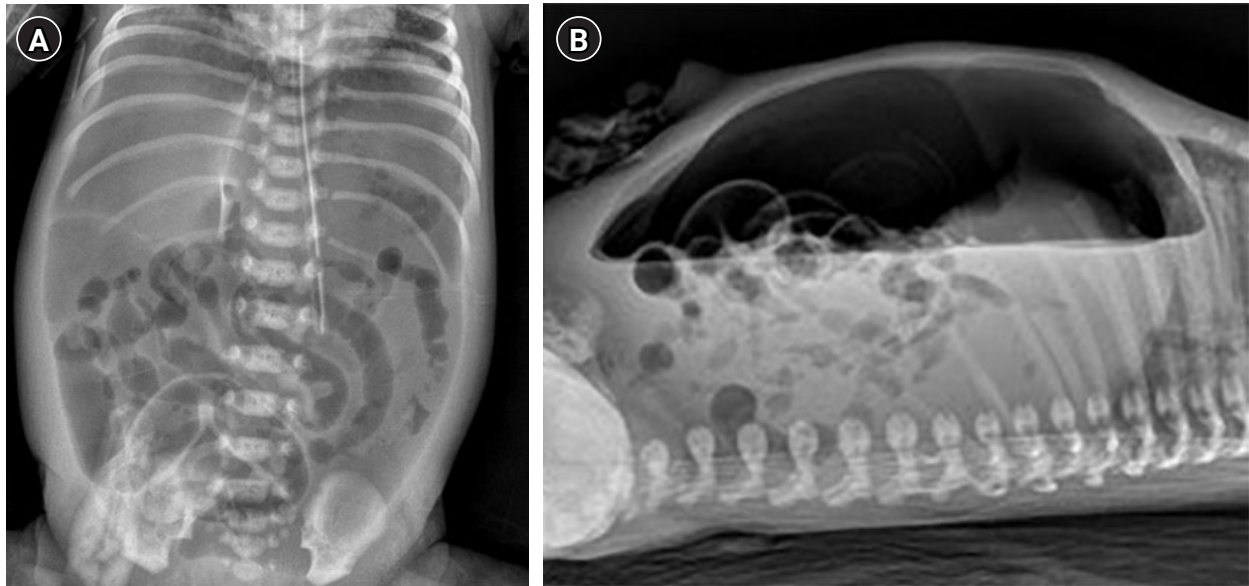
Finding of abdominal x-ray showing pneumoperitoneum. (A) Anterior posterior supine view and (B) trans-lateral view.
